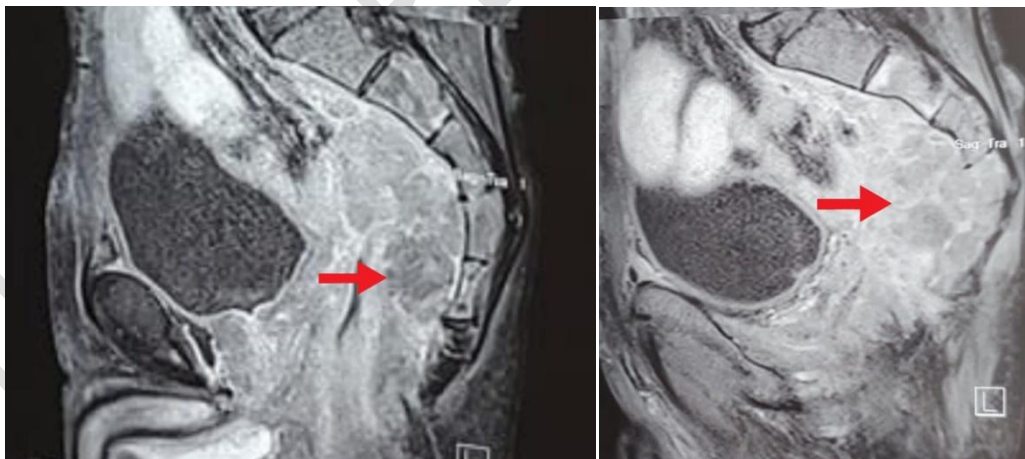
Fig5 : Sagittal-section MRI of the middle and upper rectum reveals an endo- and exophytic tissue process with heterogeneous T2 hypersignals, extending to the sigmoid loop, presacral space and sacrum.
